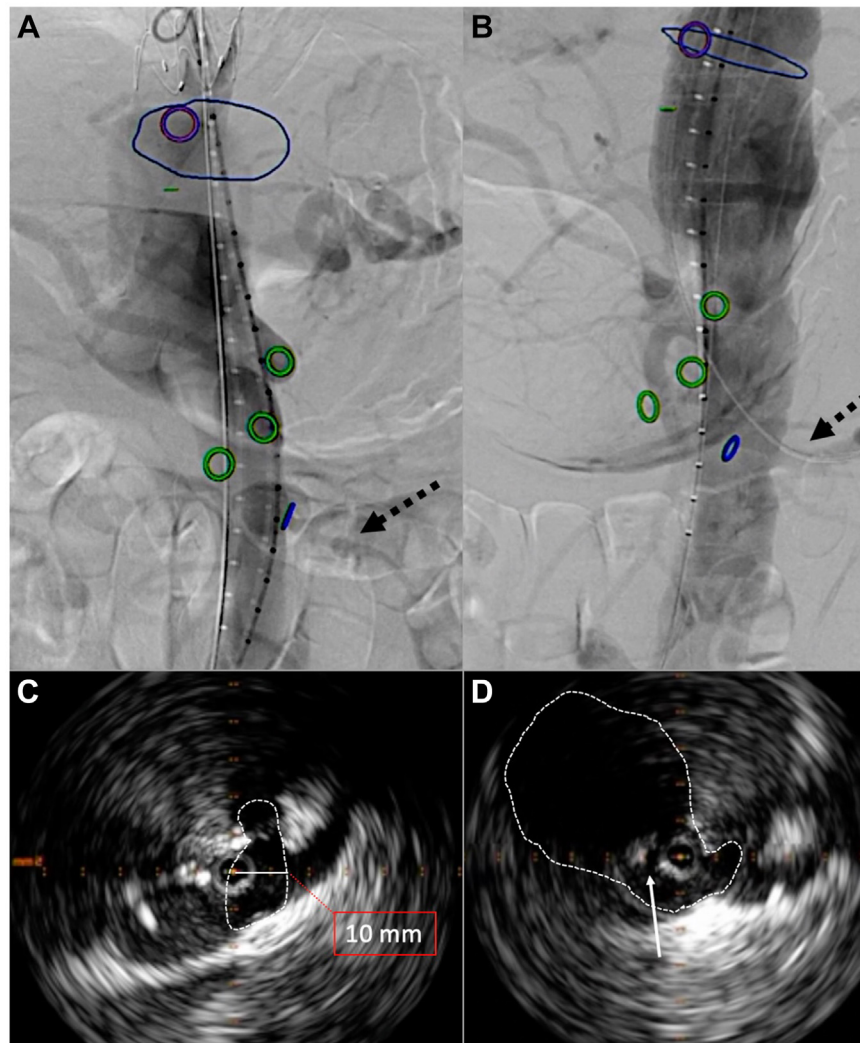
(A) Static aortic angiography before septostomy and (B) after septostomy; to note paravisceral aortic lumen diameter increase and improved left renal artery perfusion (dotted arrow). (C) Static axial intravascular ultrasound (IVUS) image of the aortic true lumen (dotted line) and diameter (solid line) at the level of the superior mesenteric artery before septostomy and (D) after septostomy; to note the increased space of true lumen (dotted line) and the cut septum (solid arrow).
